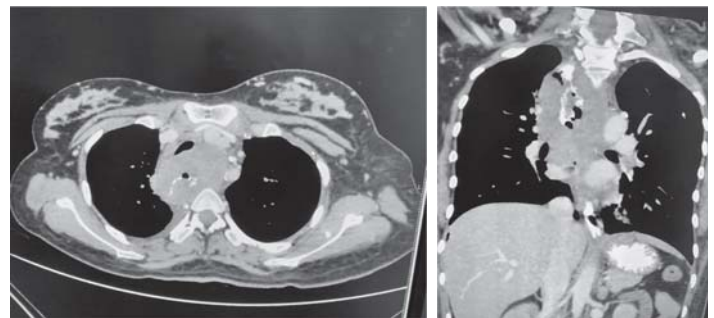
CT scan whole abdomen
